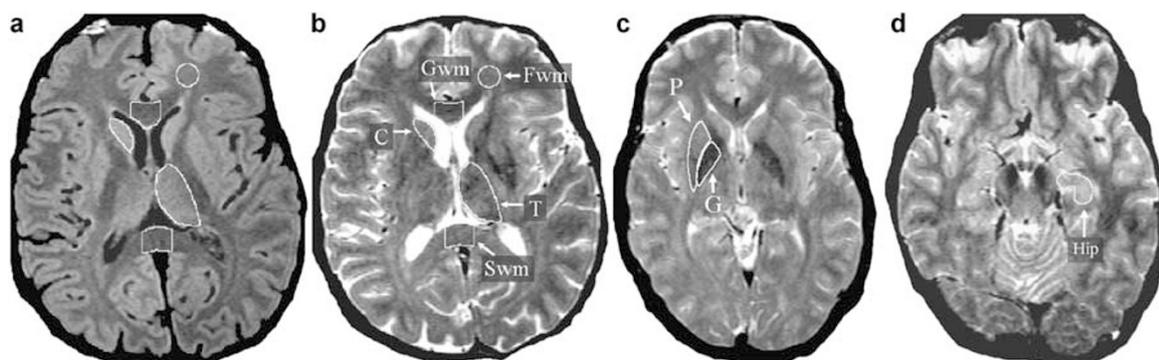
Regions of interest (ROIs). ROI definition is depicted on axial MRI TE20 (a) and TE90 (b–d). The TE20 has optimal contrast between gray (appears light gray) and white matter (appears dark gray). The TE90 has optimal contrast between brain (appears gray) and CSF (appears white). Both TE20 and TE90 images are used to draw each ROI as this combination of images maximizes contrast needed for accurate ROI definition. As an example, the use of both contrasts is depicted in the thalamus ROI that borders CSF medially and white matter laterally and posteriorly (a and b). Data for each ROI are obtained from contiguous pairs of slices. Only one hemisphere ROI is depicted on the figures although ROIs are measured bilaterally for all regions except for midline corpus callosum regions (Gwm and Swm). Please see text ('MRI Protocol') for further details.
